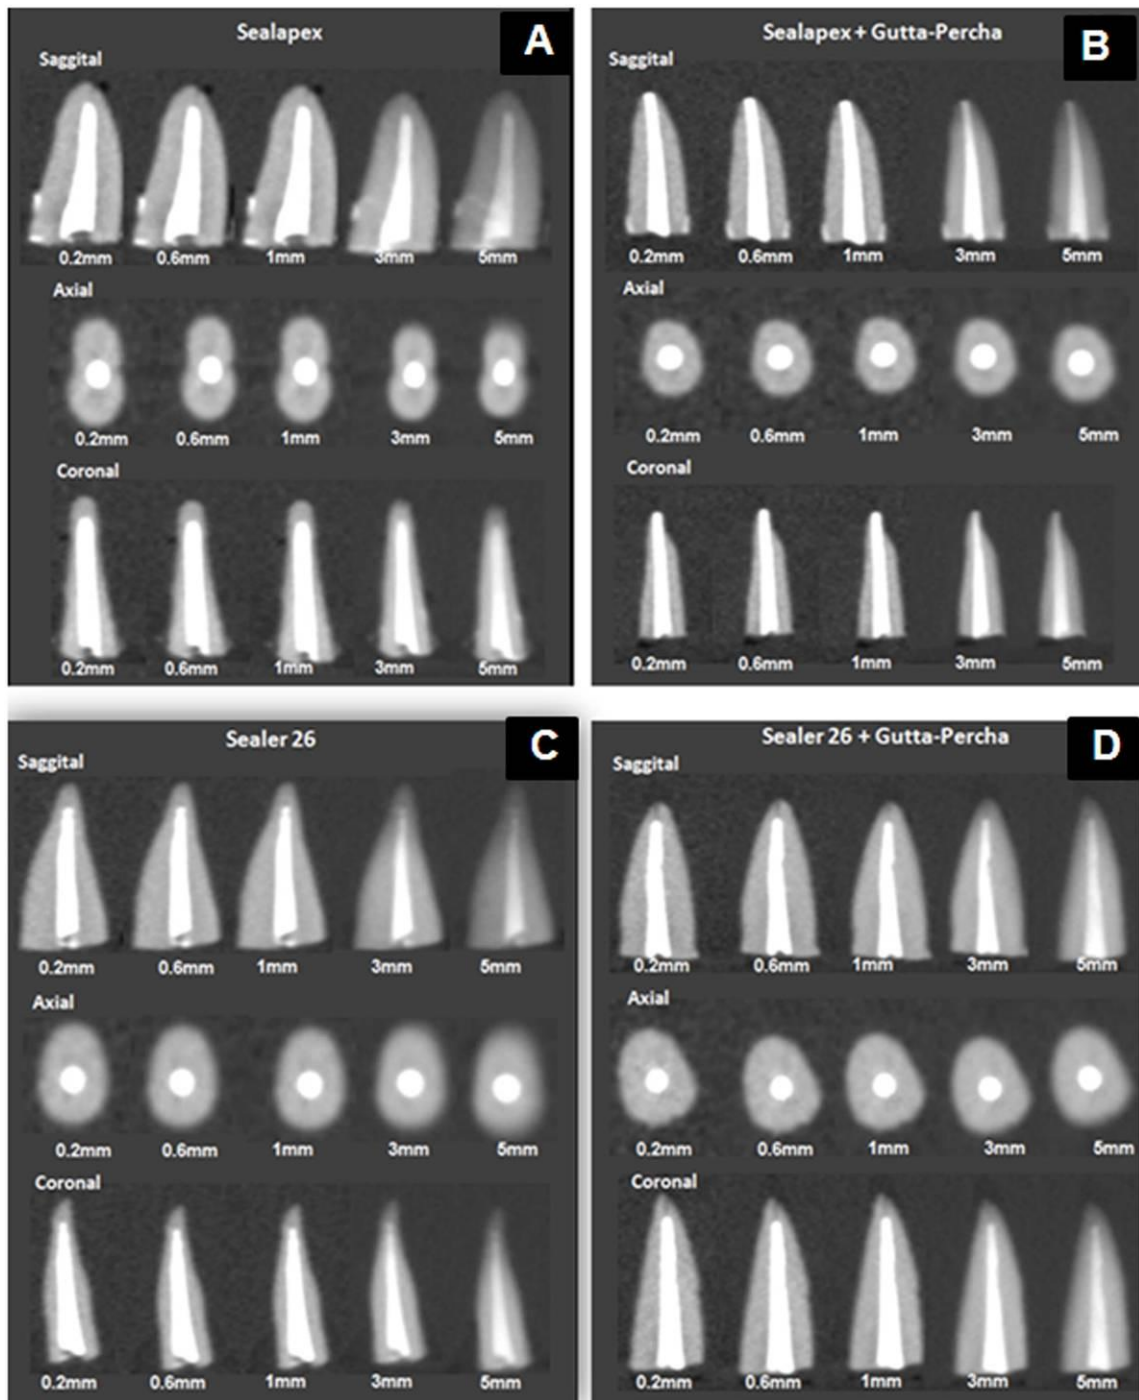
CBCT images of root canal filling with Sealapex (A), Sealapex + gutta-percha (B), Sealer 26 (C), and Sealer 26 + gutta-percha (D) in different slice thickness and planes (sagittal, axial and coronal).
